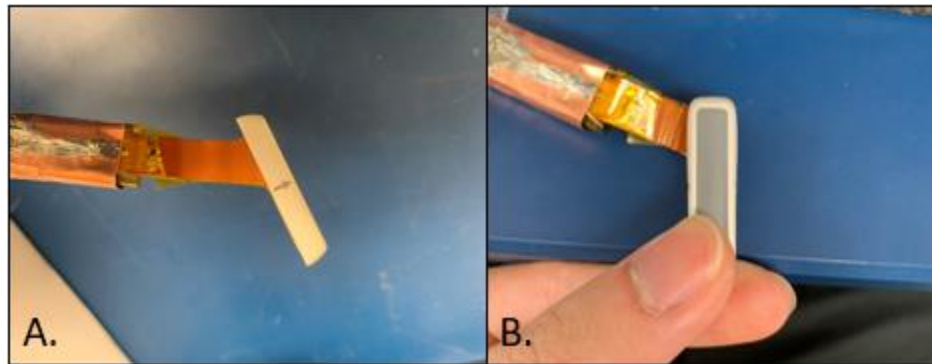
Images of the disassembled ultrasound probe. A) Unbent probe. B) Bent probe.
